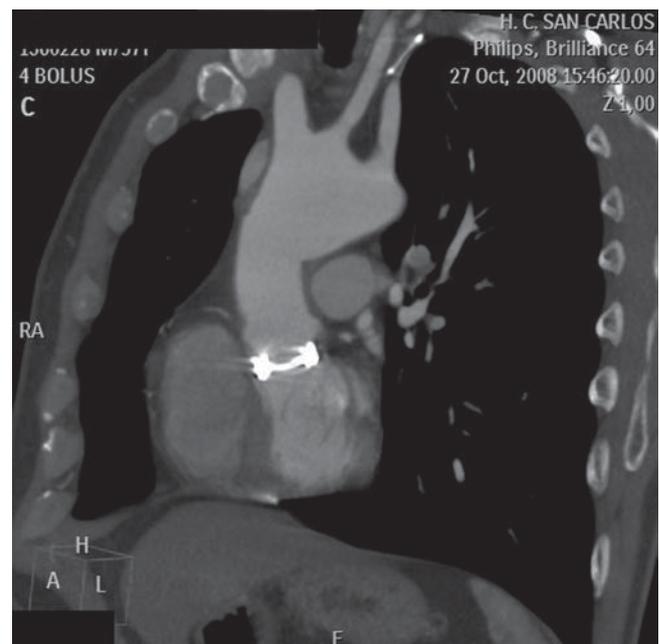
Sixty-four-row multi-slice CT obtained in the follow-up of a 57-year-old man operated 5 years ago for a severe aortic annulectasia with a Bentall and DeBono procedure. There is a moderate dilation of the aortic arch (45 mm), which includes the exit of the main arterial branches of the arch. The high attenuation generated by the metallic prostheses is clearly visible
